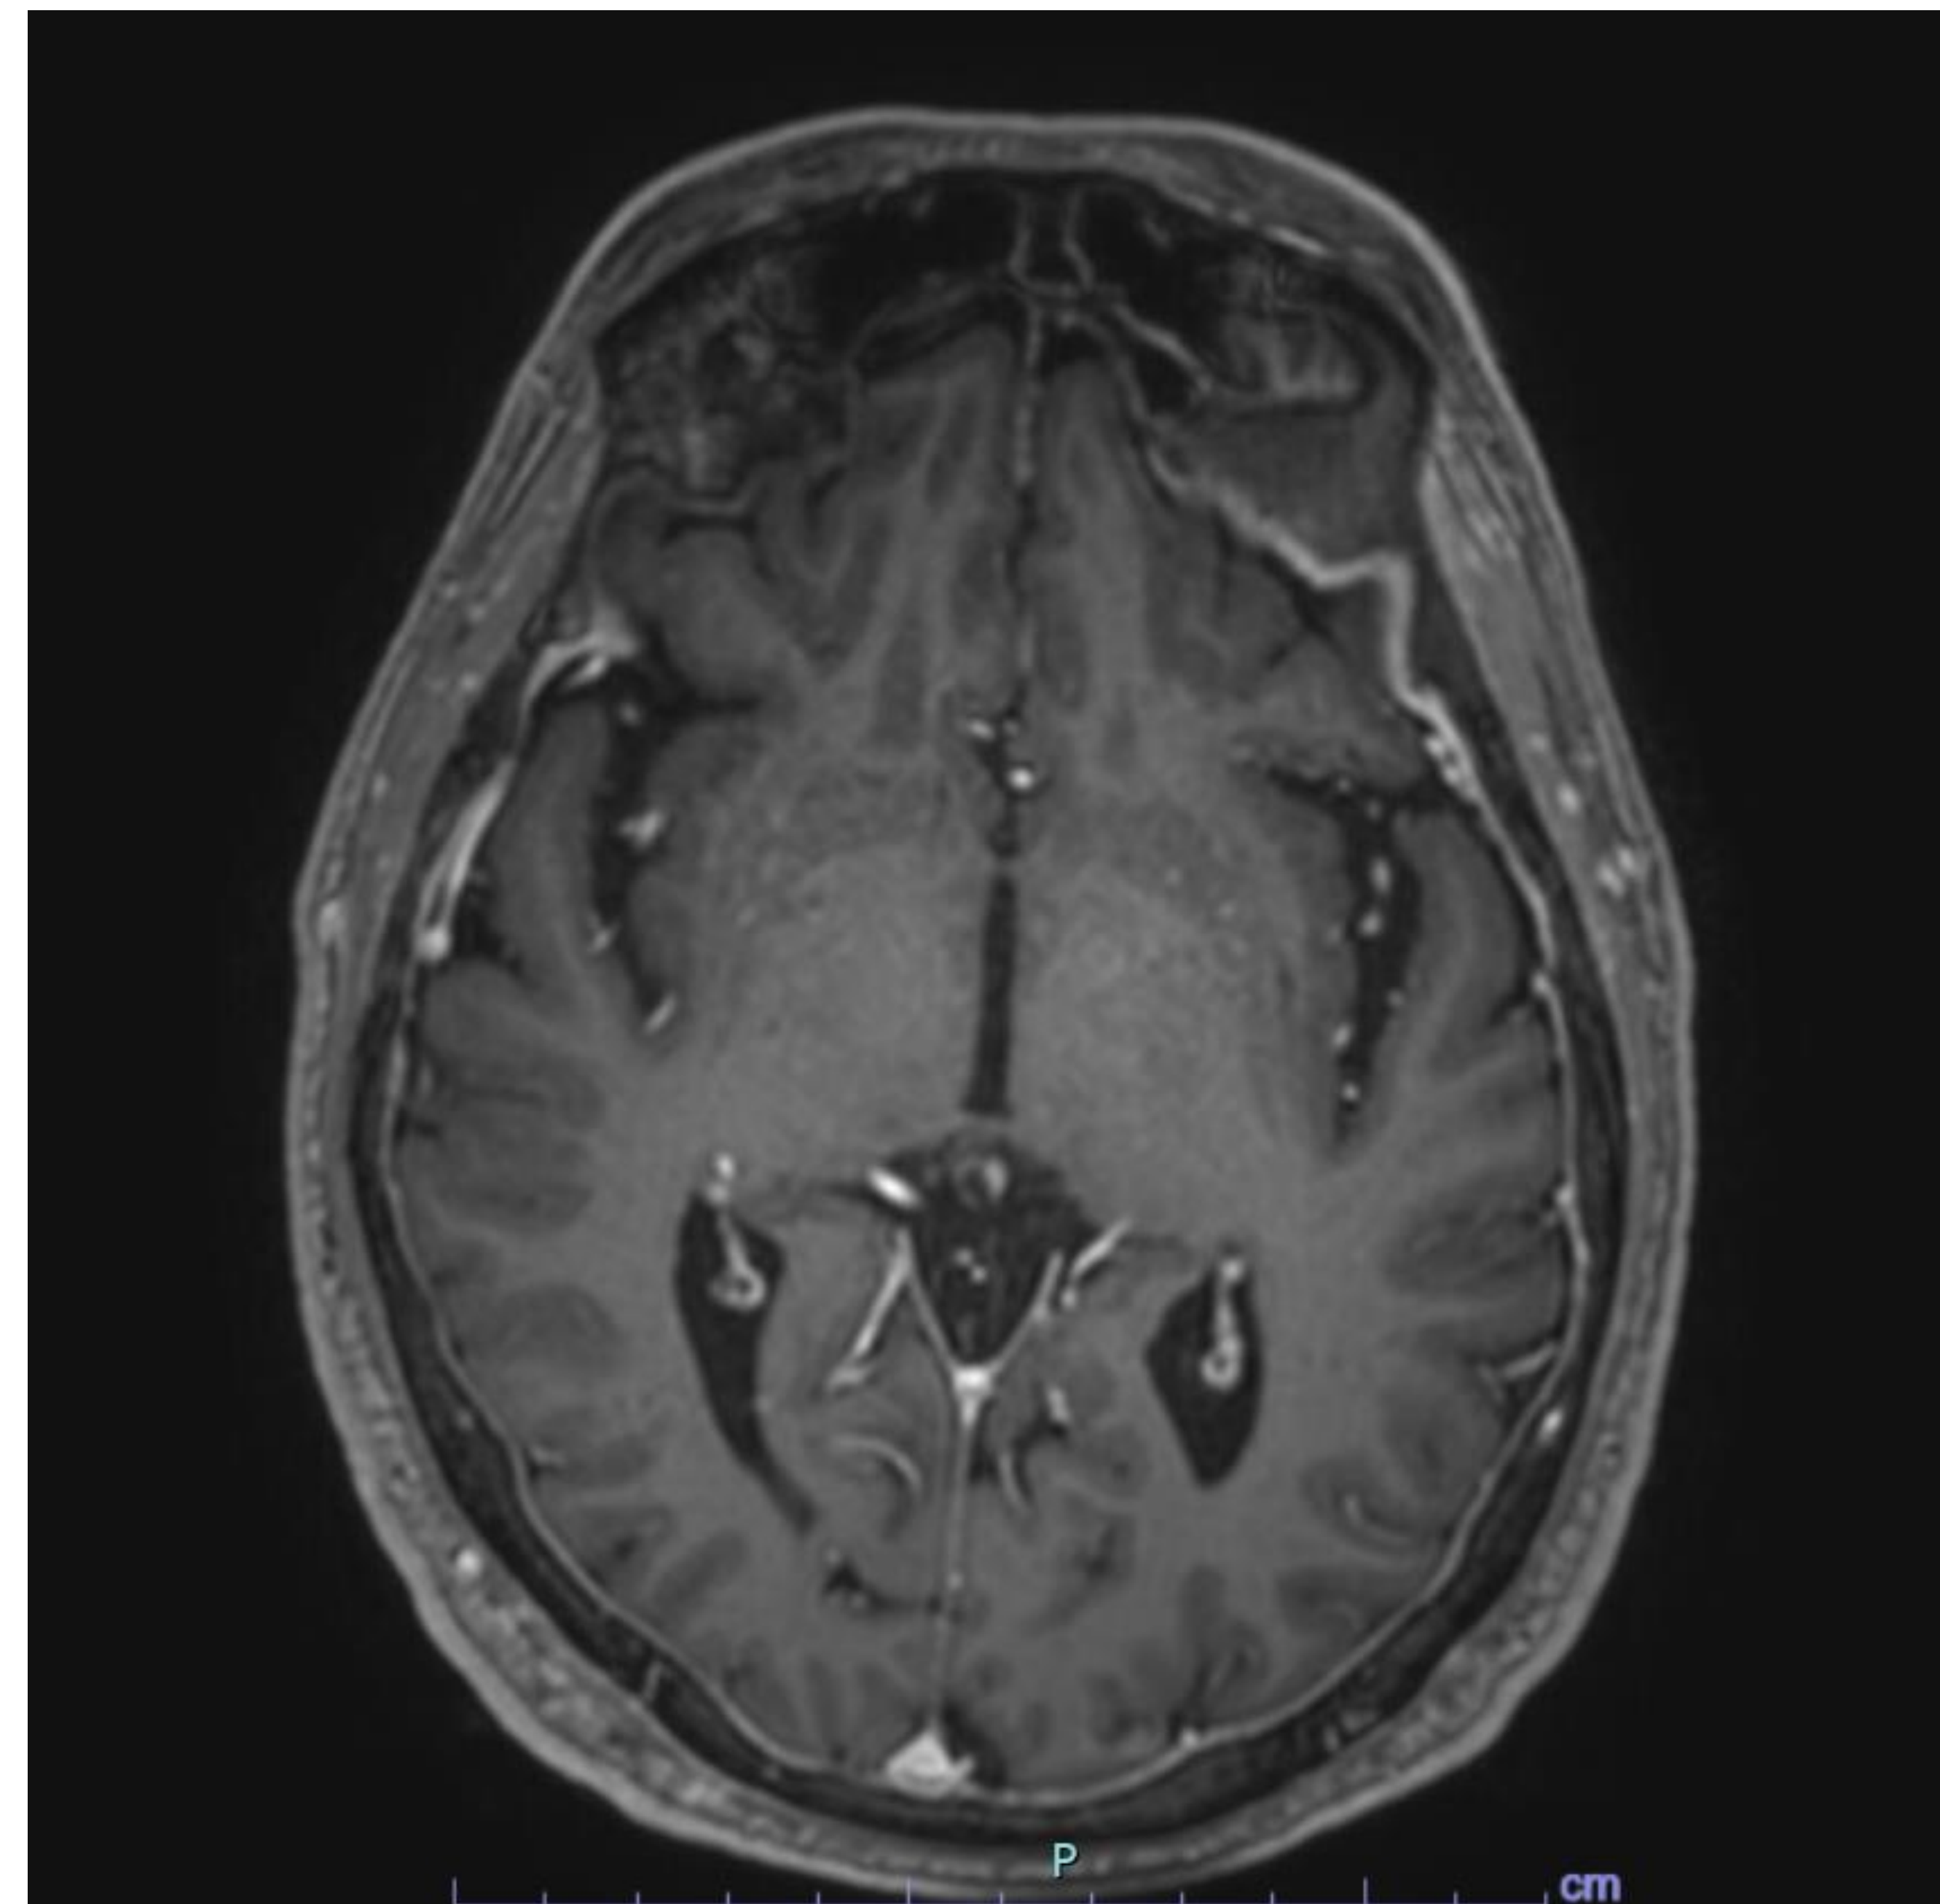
MRI Brain with mild pachymeningeal enhancement.
